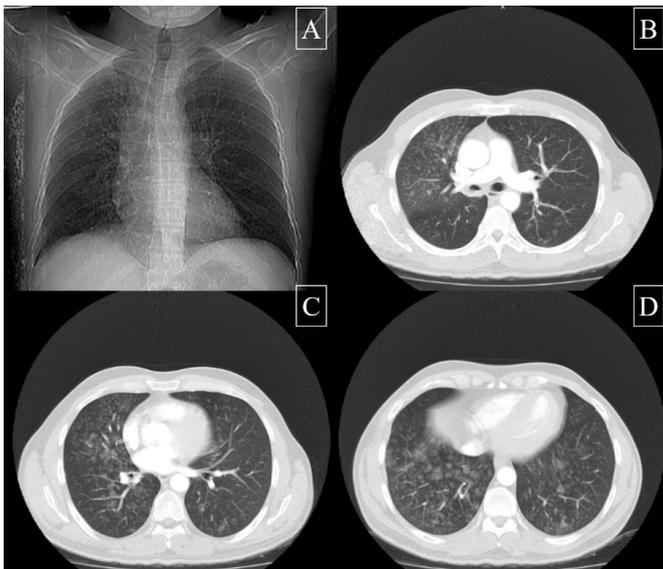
Direct radiograph and computed tomography images of the patient's lung
